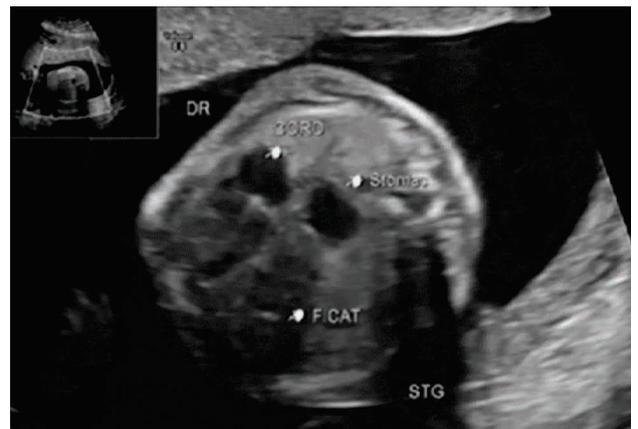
Ultrasound image of the thorax containing the herniated organs at this level
